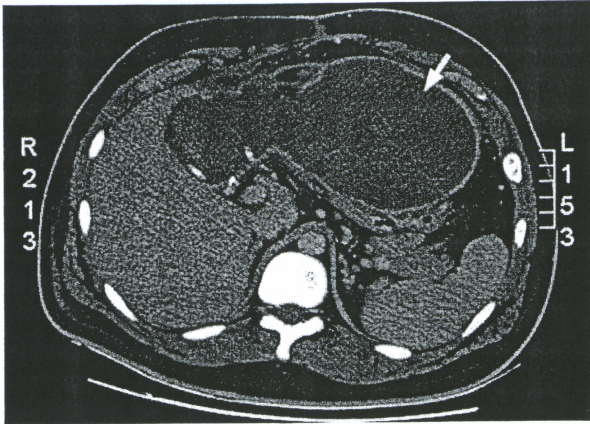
Abdominal computed tomography scan showing a lobulated biloma formation (arrow) at the subhepatic area compressing on the stomach.
